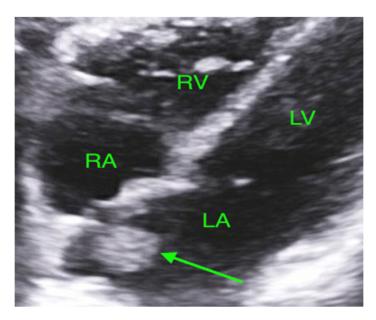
Apical four-chamber view obtained through TEE. It reveals a 2 cm x 1.8 cm mass located in the left atrium (indicated by the green arrow). Left atrium (LA), right atrium (RA), left ventricle (LV), and right ventricle (RV).
